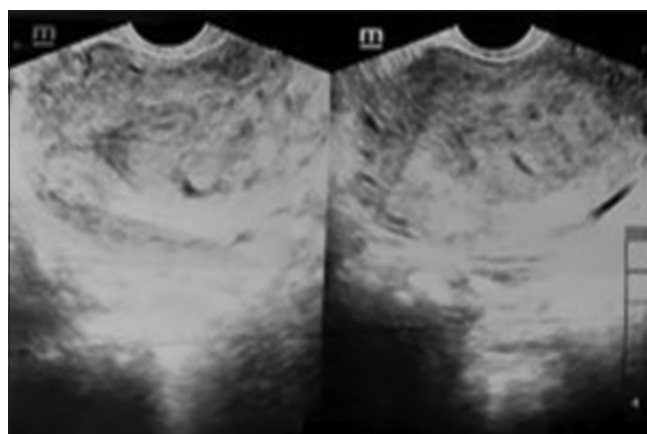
Transvaginal sonography showing slightly enlarged anteverted uterus with thickened cystic and hyperechoic endometrium to consider hydatidiform mole
